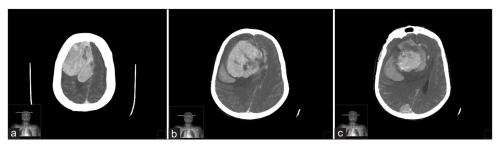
Axial CT with contrast: (a) right frontal convexity giant meningioma; (b) axial CT scan of the patient showing intracranial hemorrhage concurrent to the giant meningioma. Large peritumor brain edema and midline shift (2.5 cm) are also noted; (c) small 2 cm meningioma on the third posterior of the SSS.
